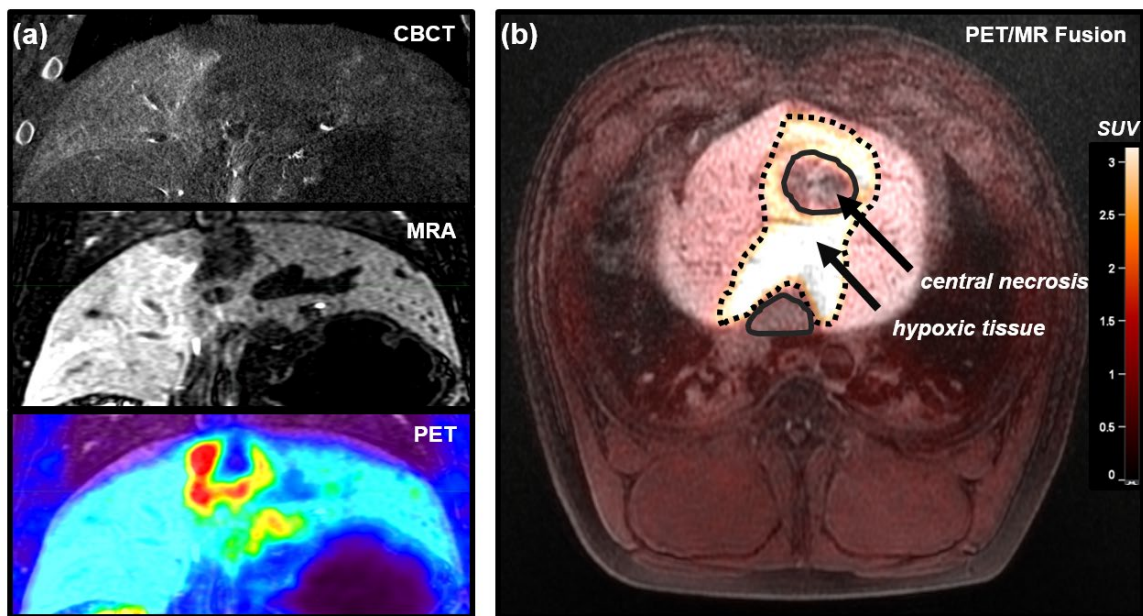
Representative F18-MISO PET/MR images
